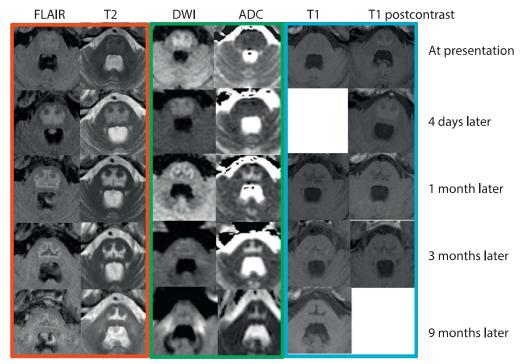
Mental status change following orthotopic liver transplant. T2 and FLAIR images demonstrate an initial increase in abnormal signal between presentation and the 4-day follow-up study with progressive decrease in signal and size of abnormality involving the central pons over time (red box). Diffusion-weighted imaging (DWI) and apparent diffusion coefficient (ADC) images demonstrates mildly restricted diffusion early that is replaced by T2 "shine-through" effect in later stages (green box). In addition, active wallerian degeneration is seen to involve the middle cerebellar peduncles at 9-month follow-up related to pontocerebellar disconnection. T1 and T1 postcontrast images demonstrate subtle early-phase enhancement that resolves in later stages (blue box). There is progressive decrease in size of T1 hypointensity corresponding to sites of T2 signal abnormality in the later stages suggesting volume loss.
